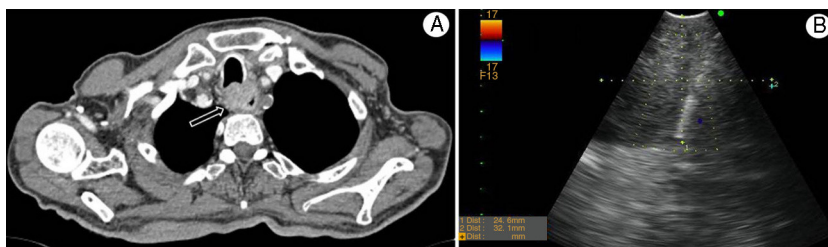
(A) Chest CT image in which a mass situated in the upper third of the esophagus can be seen (indicated with an arrow). (B) Endoscopic ultrasound image of the esophageal mass needle aspiration.
